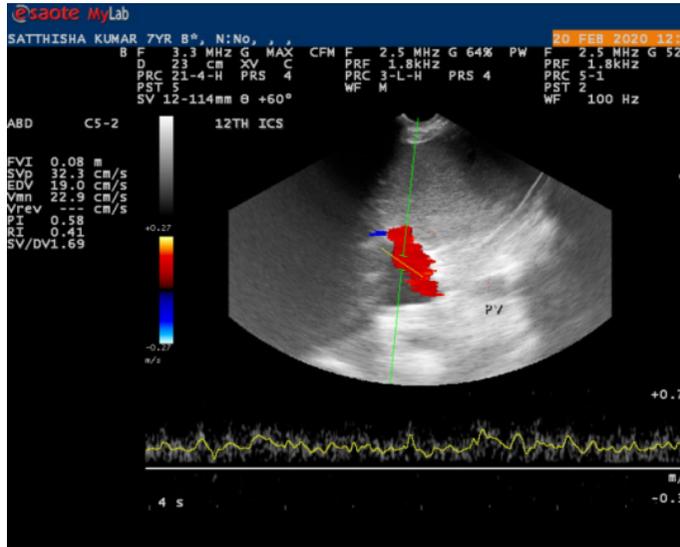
Spectral display showing doppler scan of PV.
